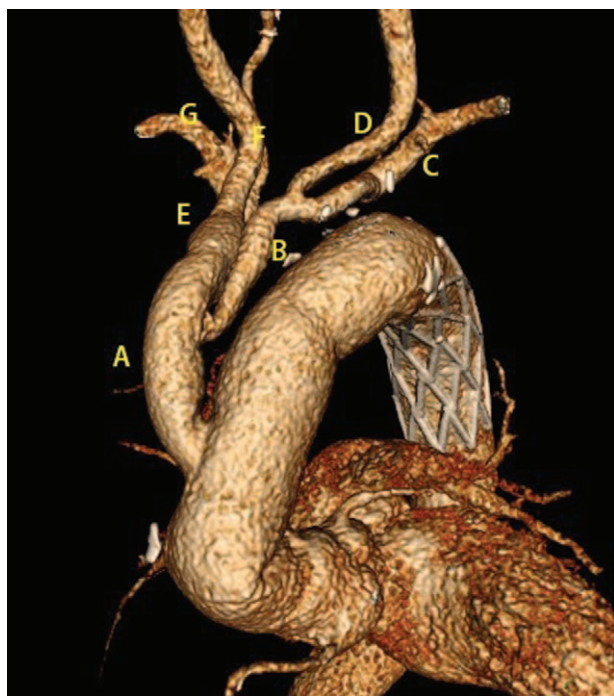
The image of CT angiography after 6 months in the 62-year-old man with arch lesions receiving a branch-first technique combined with Sun's procedure using a "Y" shaped graft. A: The graft trunk; B: The graft side arm; C: Left subclavian artery; D: Left common carotid artery; E: Innominate artery; F: Right common carotid artery; G: Right subclavian artery.
